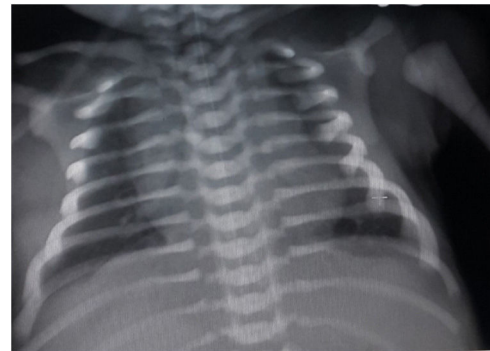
X-ray of the chest with increased rib and arm bone density.
